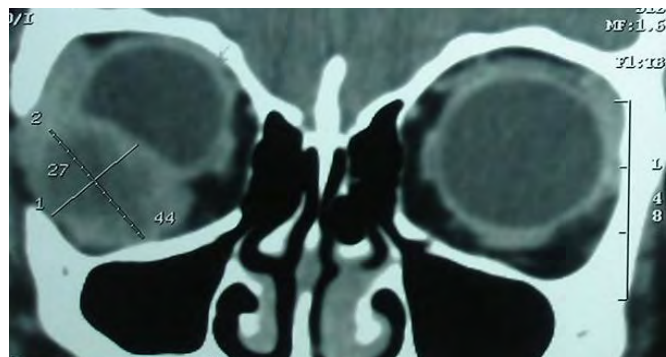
Coronal cut of CT scan showing well defined mass inferotemporally suggestive of abscess formation
